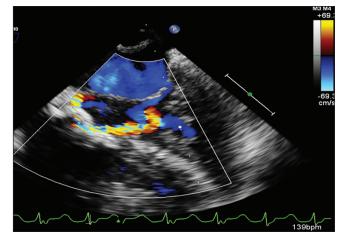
Postoperative midesophageal four chamber view with color flow Doppler shows right to left shunt across the unidirectional flap valve used to close the ventricular septal defect
